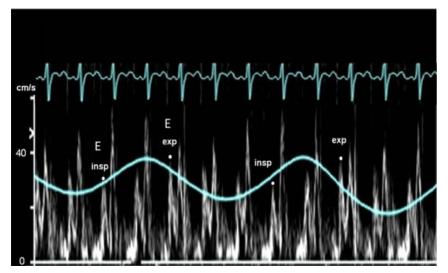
PW Doppler recording of mitral inflow with a respirometer in a patient with cardiac tamponade. Peak velocities and velocity-time integrals are low, reflecting the reduced cardiac output. There is increased respiratory variation in peak E-wave inflow (E) velocity compared with normal, with the lowest values on the first beat of inspiration (insp) and the highest values on the first beat of expiration (exp). The beats in between inspiration and expiration have intermediate values. From expiration to inspiration, the decrease in peak mitral E-wave velocity exceeds 30%, as is typical in significant tamponade. Note that percentage of respiratory variation for mitral inflow should be calculated as (expiration – inspiration)/expiration based on the consensus of the Writing Group.
